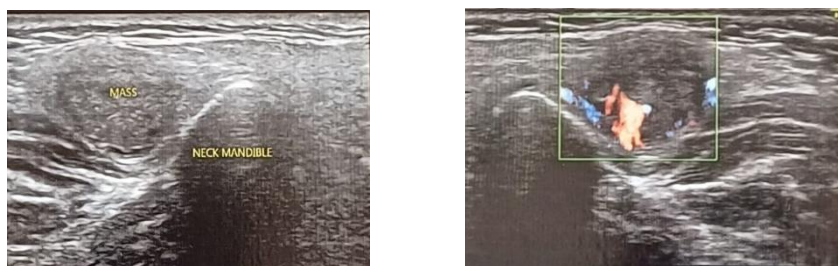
Ultrasonographic images of the left preauricular region demonstrating a well-defined lesion with mixed echogenicity, small internal cystic areas, and internal vascularity on Color Doppler.
